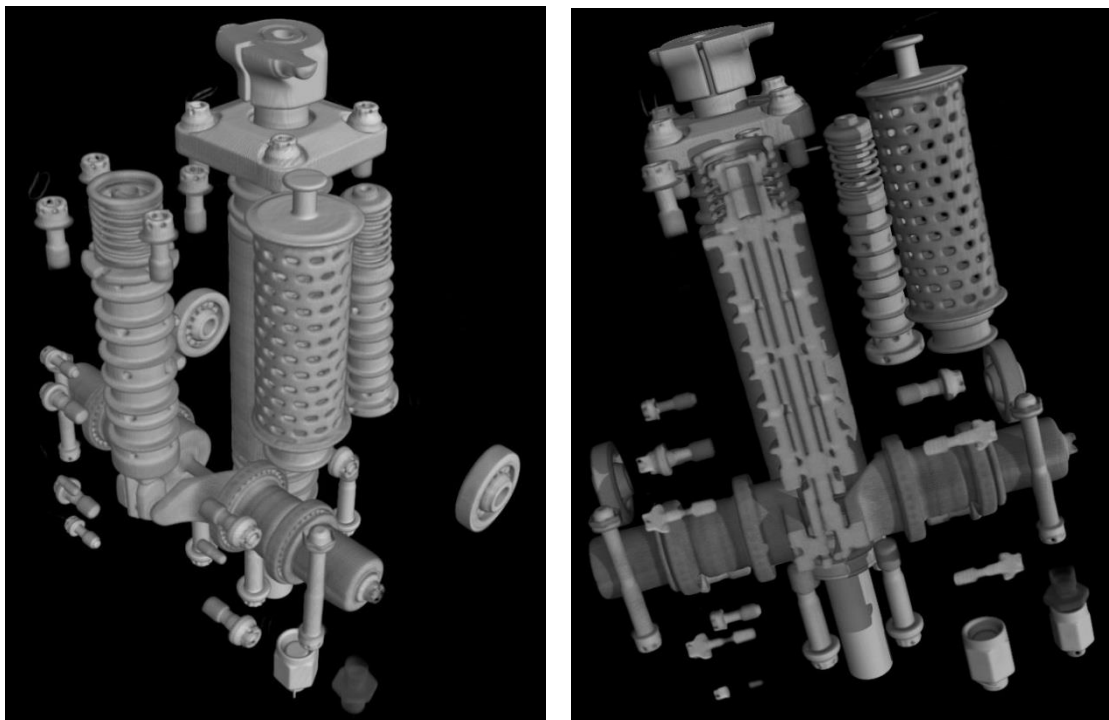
Example images from the CT scan. Photo: NTSB
